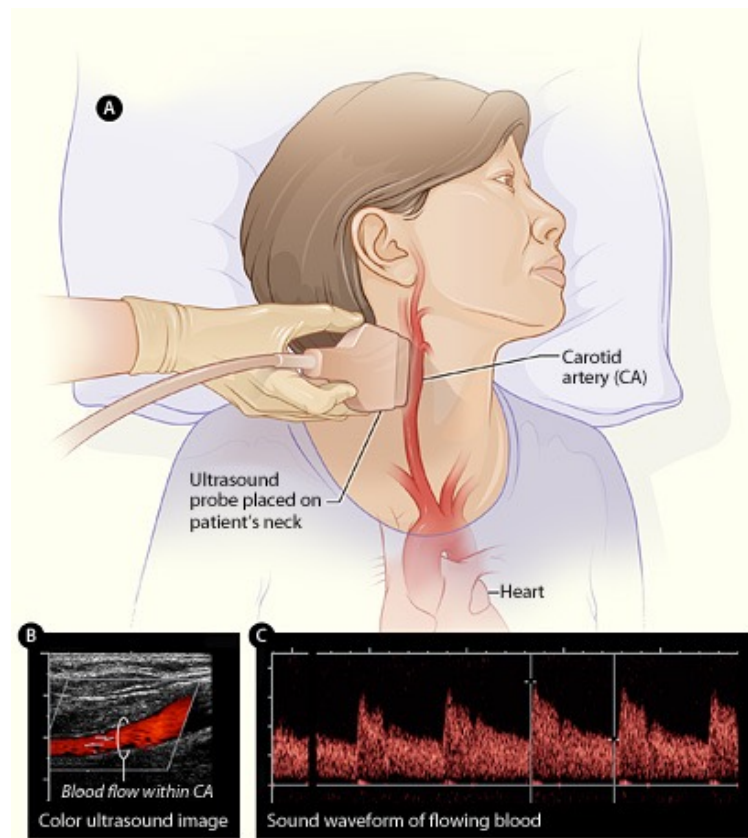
Ultrasound of carotid artery: (a) ultrasound probe (transducer); (b) color ultrasound image of blood flow; (c) waveform image of sound of flowing blood
